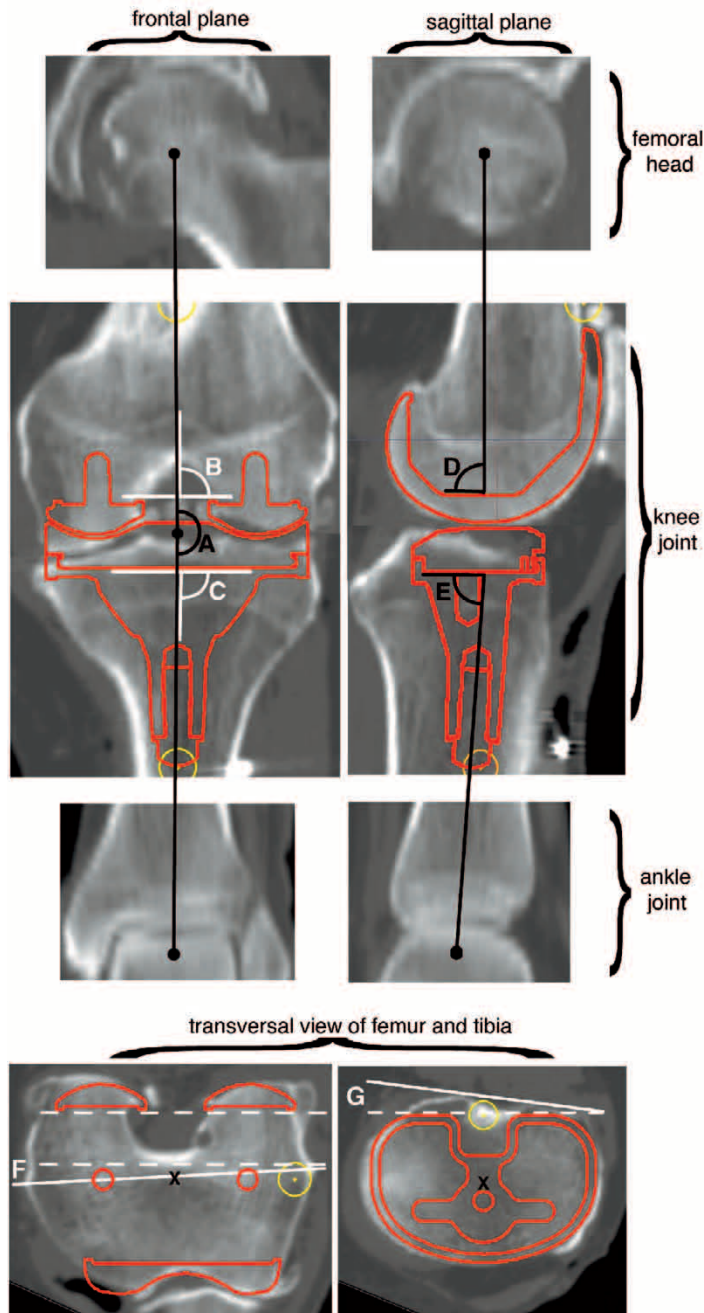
Preoperative CT-scan of the femoral head, the knee and the ankle joint as seen in the planning software. Red outlines represent the tibial and femoral components. The surgeon determines size, position and alignment of the virtual components. The following parameters are adjusted in the preoperative CT to determine the cutter path of the robot:
